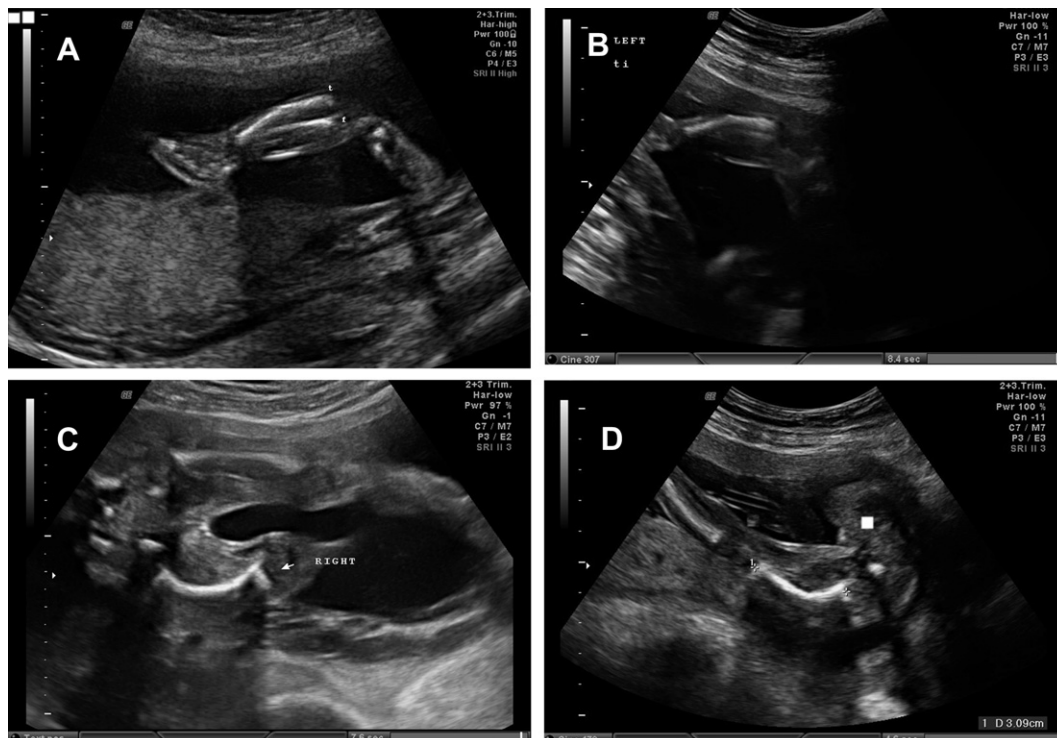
Prenatal ultrasound at 22 weeks of gestation shows: (A) curved left tibia and straight left fibula; (B) curved left tibia; (C) straight left femur and curved right femur; and (D) curved right femur. f = fibula; t = tibia.
